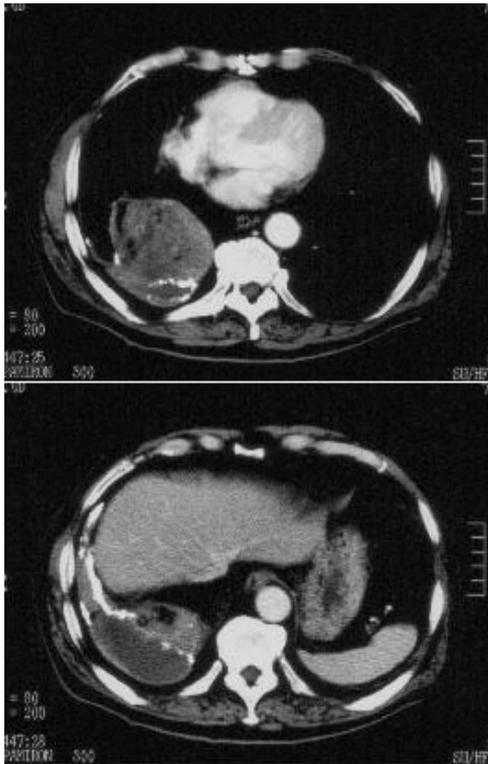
Pretreatment enhanced chest CT showing a huge mass shadow connected to the CP cavity in the lower lobe of the right lung.
